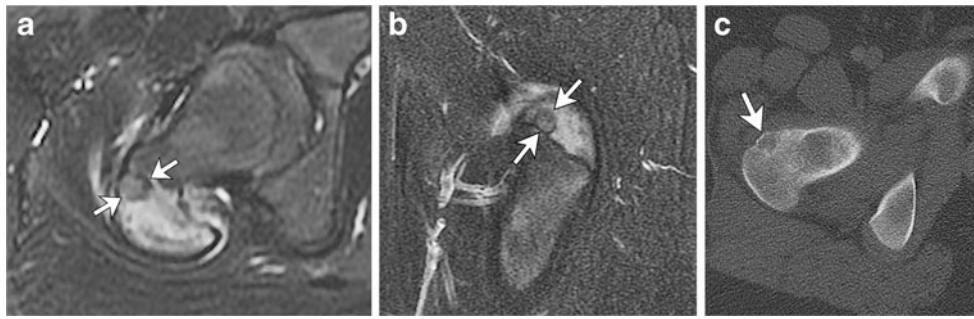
Images in a 13-year-old boy with right hip pain for 5 months, radiating down the leg. Axial (a) and sagittal (b) fat-saturated T2-weighted images of the right greater trochanteric apophysis demonstrate marrow edema with a rounded lesion and peripheral hypointensity (*arrows*). There is mild edema within the adjacent soft tissues. As the apophysis is an unusual location for osteoid osteomas, a CT was
